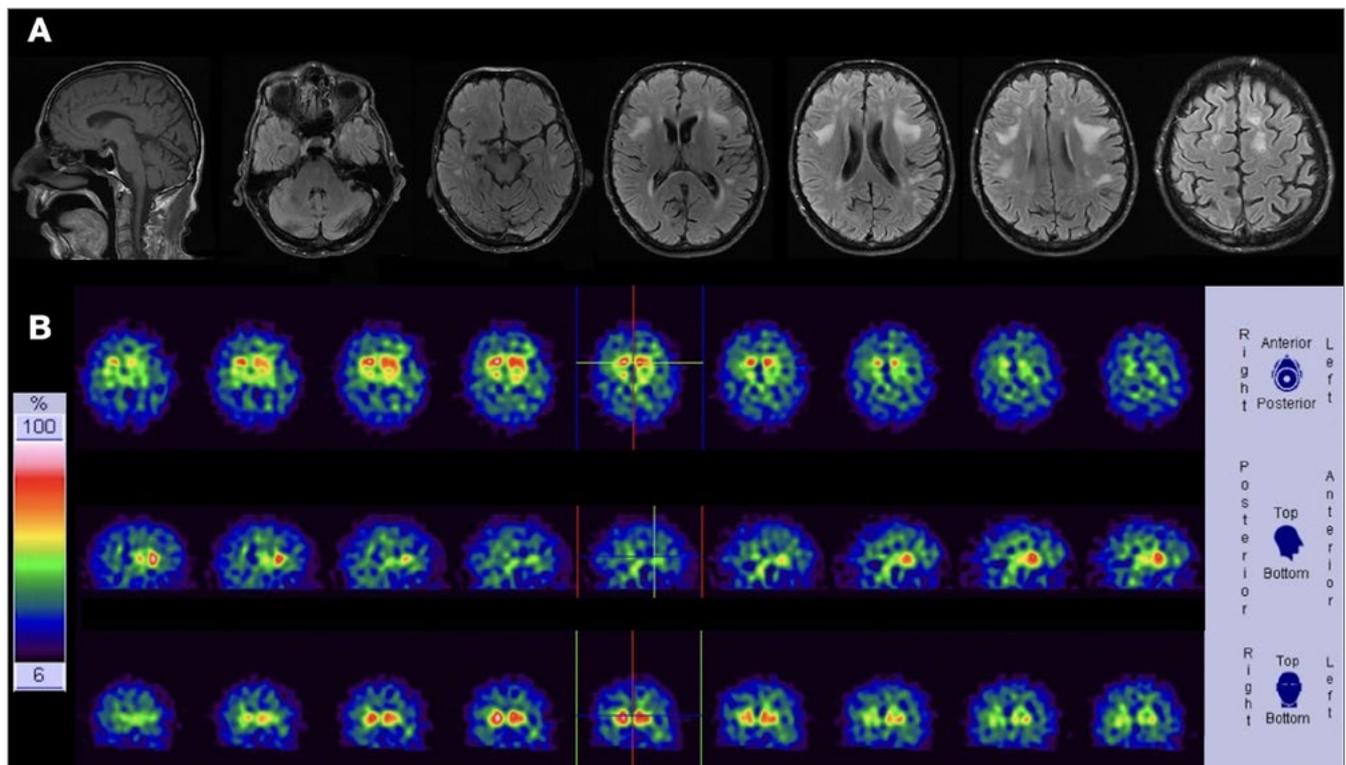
Structural and functional brain imaging of case 1. Brain sagittal and axial brain MRI sequences (A), and loflupane(¹²³I)-FP-CIT SPECT (B).
